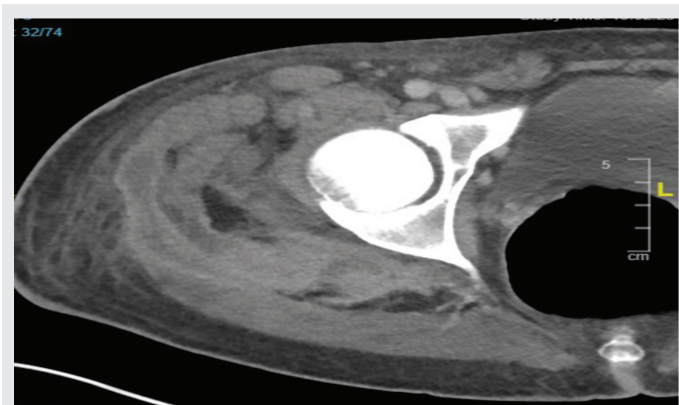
Computed tomography scan of the hip of the patient showing features of osteomyelitis and abscess.
